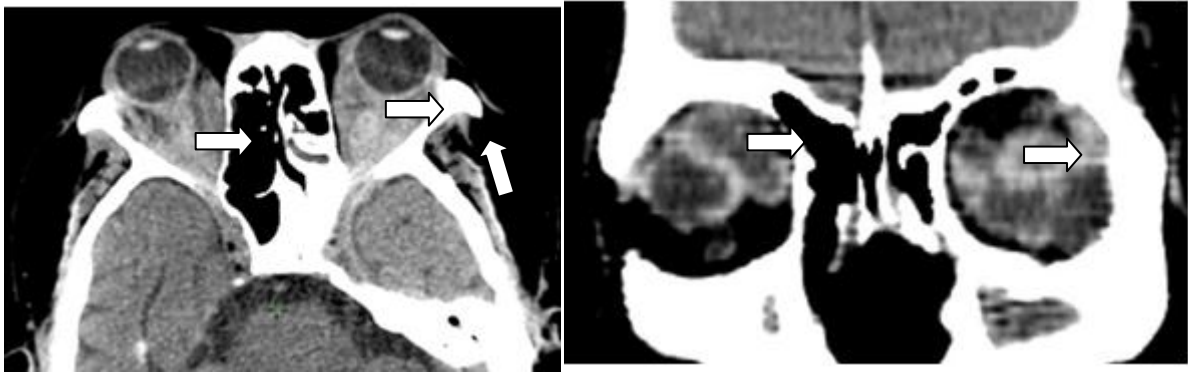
enhanced CT-scan showing : 02 intraconic and retrocular masses surrounding the optic nerve and repressing the oculomotor muscle that is heterogeneously enhanced
